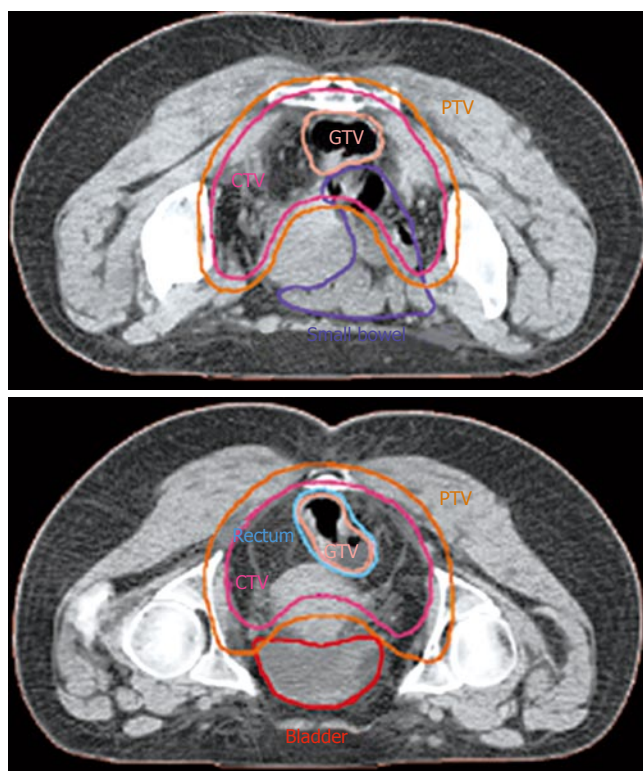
The GTV, PTV and organ at risk (small bowel and bladder) countered on the axial CT slices.
